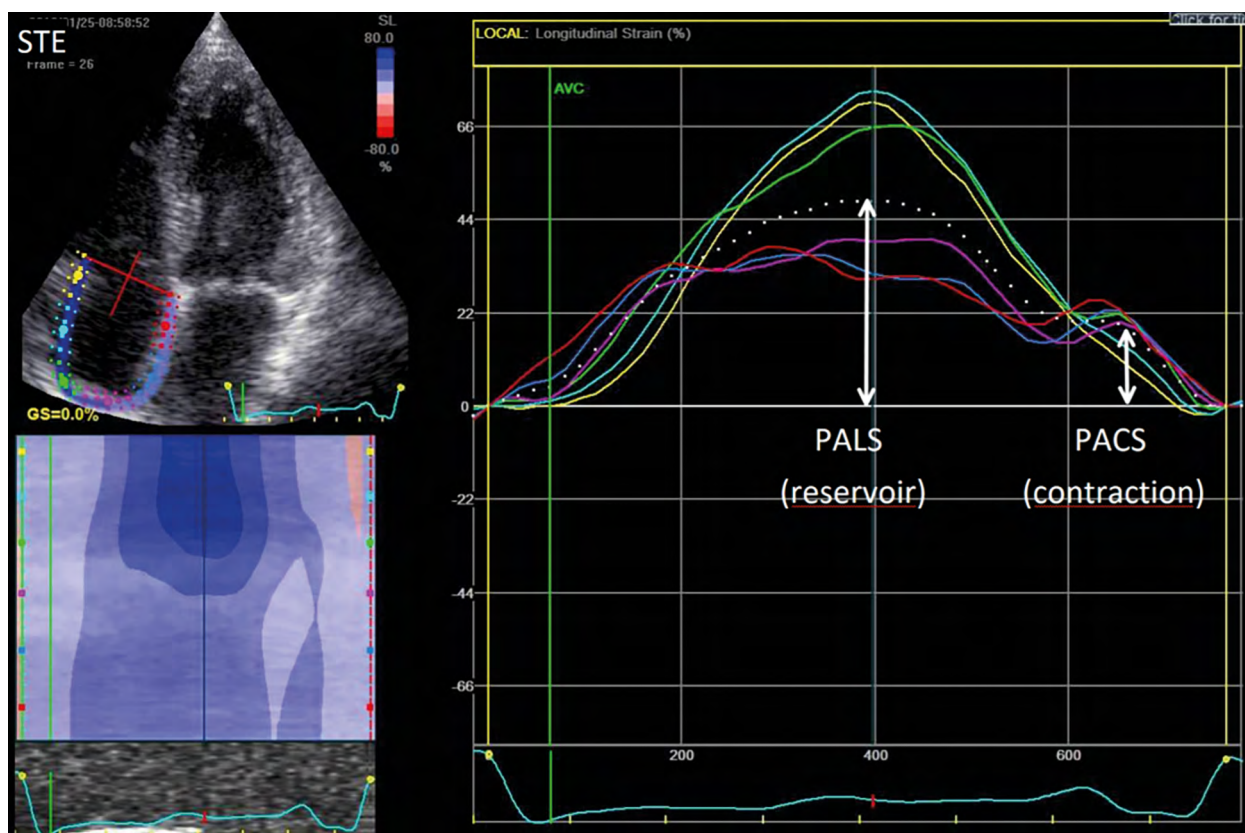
Speckle tracking assessment of the right atrium with measurement of PALS and PACS; PACS – peak atrial contraction strain; PALS – peak atrial longitudinal strain; STE – speckle tracking echocardiography
